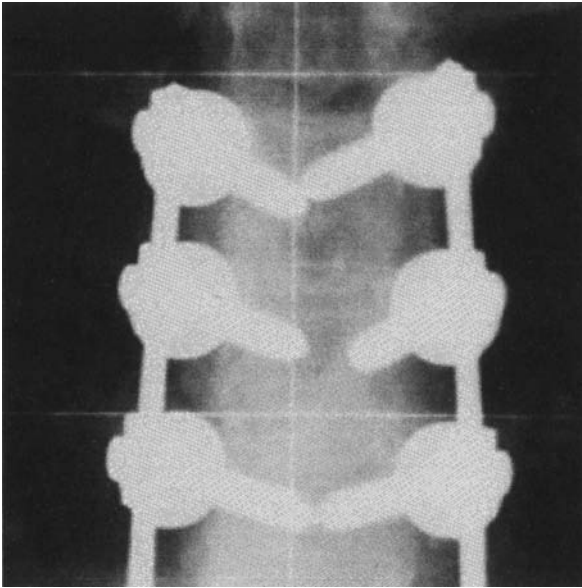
AP x-ray (close-up view) of upper thoracic spine demonstrating extrapedicular screws with far lateral entry point.
